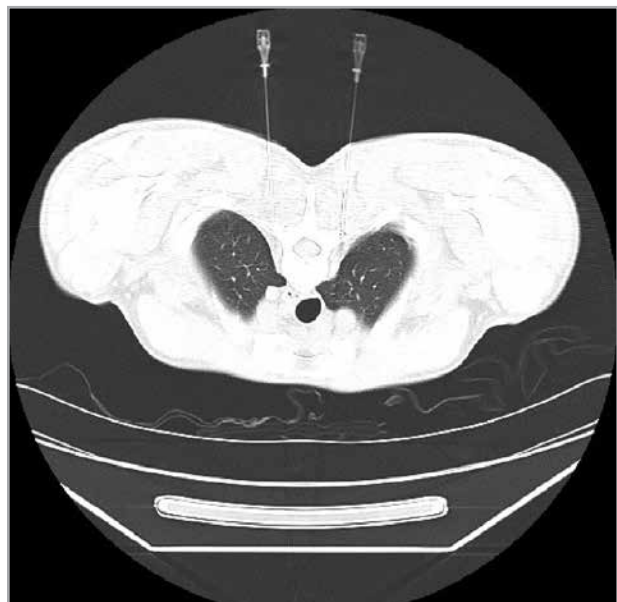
Computed tomography (CT) examination of the patient's T4 plane during the operation.
